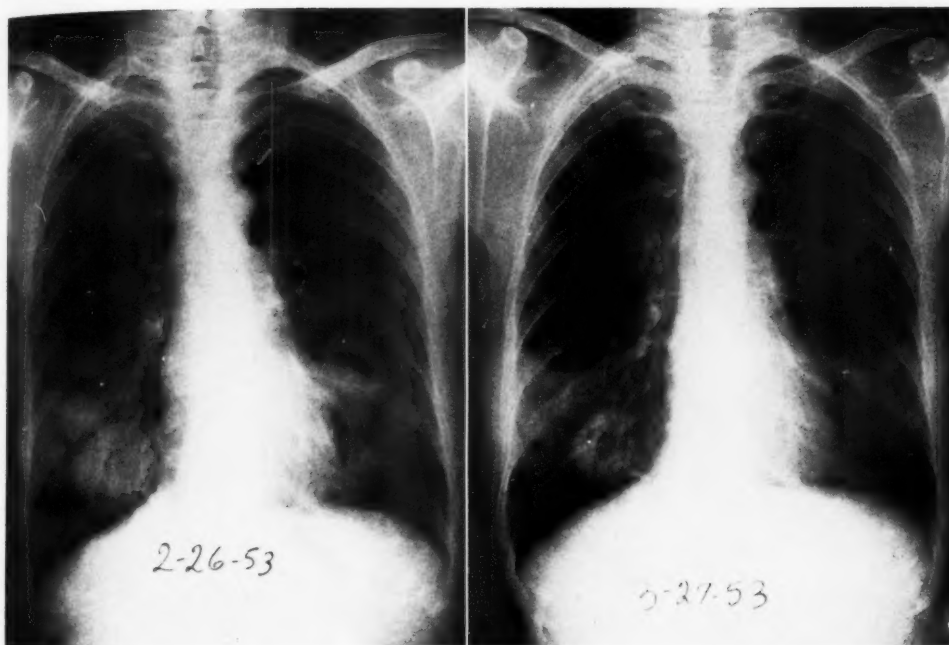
Feb. 26, 1953. Subjective symptomatology (tightness in the chest) preceded the appearance of positive roentgen findings. A film taken only a few months prior to this one was essentially negative. Parenchymal infiltration is seen at both bases.
